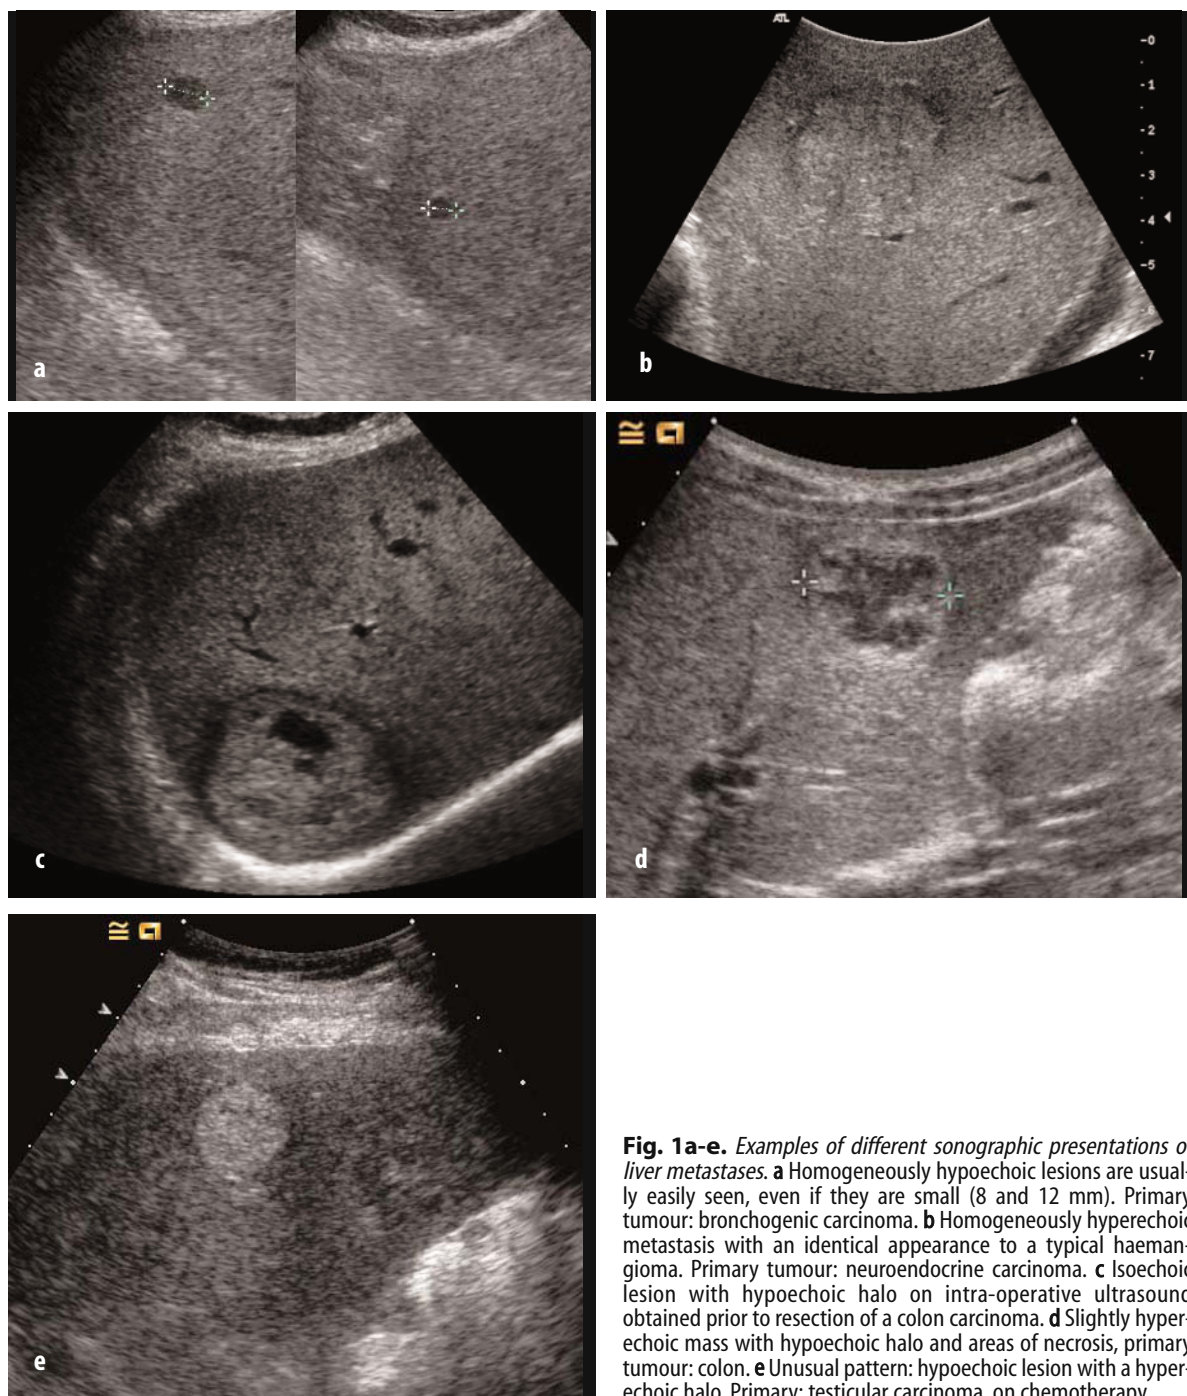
Examples of different sonographic presentations of liver metastases. a Homogeneously hypoechoic lesions are usually easily seen, even if they are small (8 and 12 mm). Primary tumour: bronchogenic carcinoma. b Homogeneously hyperechoic metastasis with an identical appearance to a typical haemangioma. Primary tumour: neuroendocrine carcinoma. c Isoechoic lesion with hypoechoic halo on intra-operative ultrasound obtained prior to resection of a colon carcinoma. d Slightly hyperechoic mass with hypoechoic halo and areas of necrosis, primary tumour: colon. e Unusual pattern: hypoechoic lesion with a hyperechoic halo. Primary: testicular carcinoma, on chemotherapy
